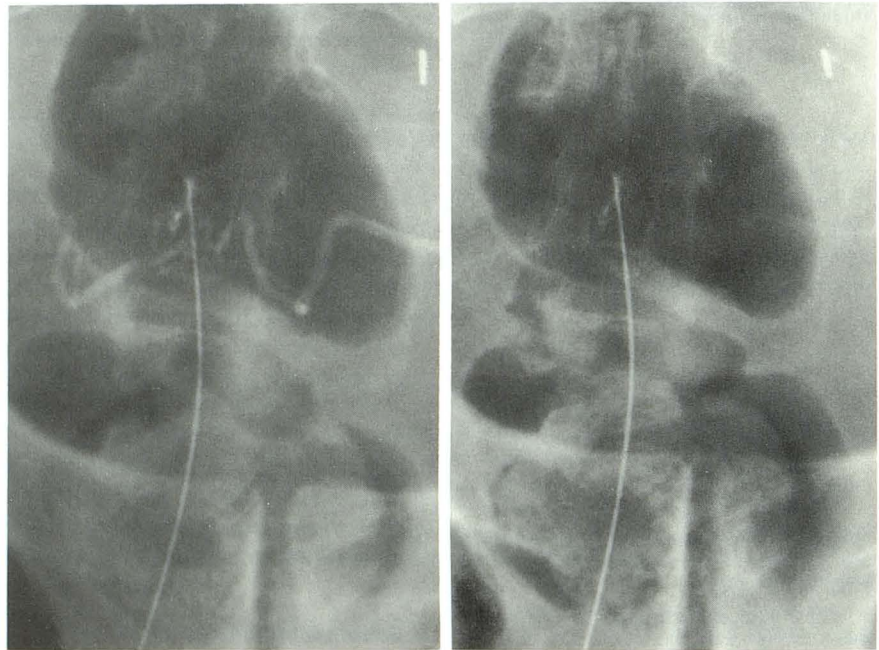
Radiographs showing IV needle placement. A, Contrast material is tubular in appearance. B, 20 sec after injection, contrast material has cleared from the veins.
